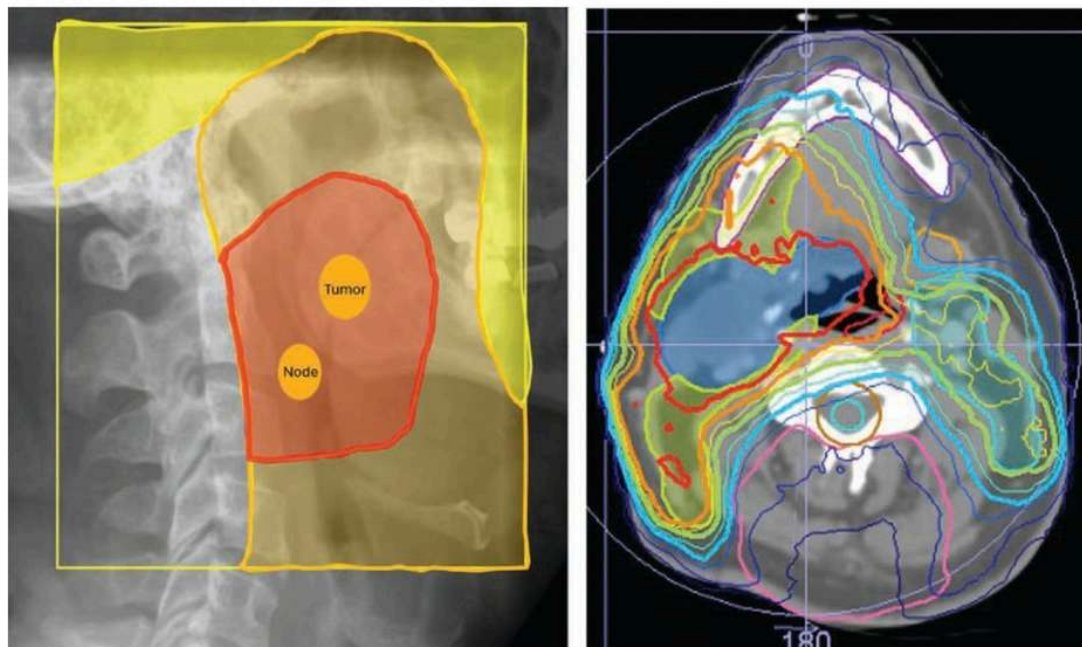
Fields vs volumes: Treatment plans for T2N1 tonsil squamous cell carcinoma. 2D radiation fields (left) 2D field based on plain film imaging and bony anatomy. The initial field is blocked out in yellow, with subsequent shrinking fields of orange and then red as a final boost. Minimal critical structures were spared. IMRT plan (right) shows the delineated tumor volumes covered conformally with high-dose radiation and risk-based coverage of at-risk lymph nodes with sparing of normal organs.
